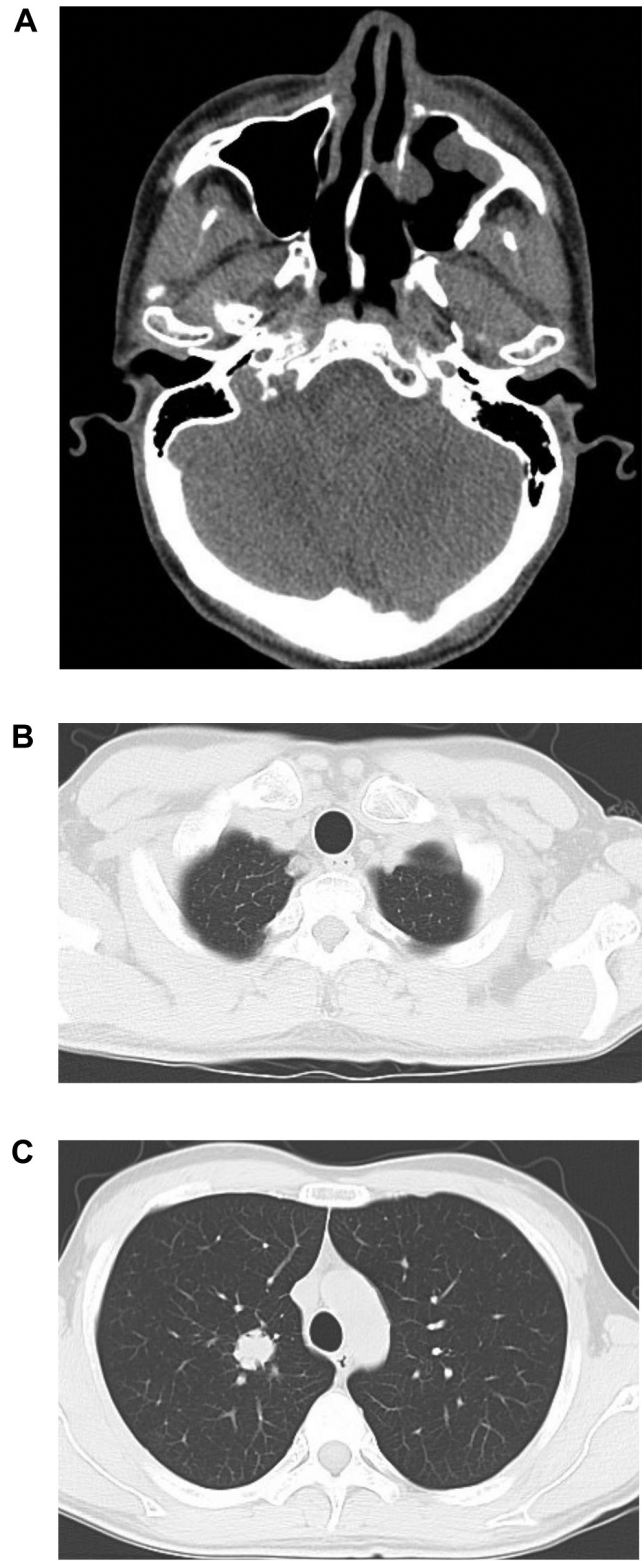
Initial computed tomography after concomitant chemoradiotherapy (axial plane). A: The mass in the left maxillary sinus had shrunk. B: A 20-mm nodule shadow is apparent in the right lung (S1). C: A nodule shadow is apparent in the right pulmonary apex.
